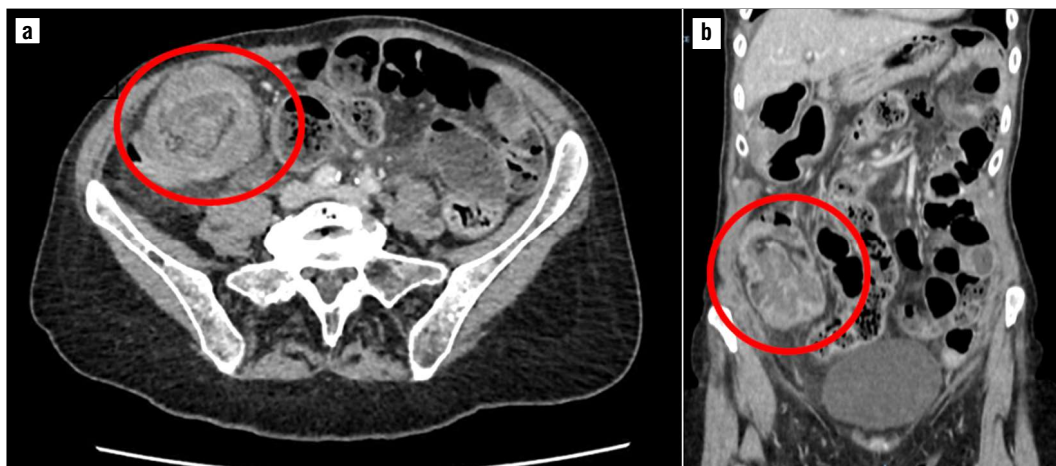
Abdominal and pelvic CT scan. (a) Cross sectional image: ileocolonic intussusception image circled in red. (b) Longitudinal image: fusiform mass circled in red
